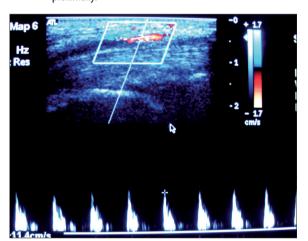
Pulse Doppler in the patent segment of persistent median artery showing dampened flow due to distal thrombus occluding the lumen.
